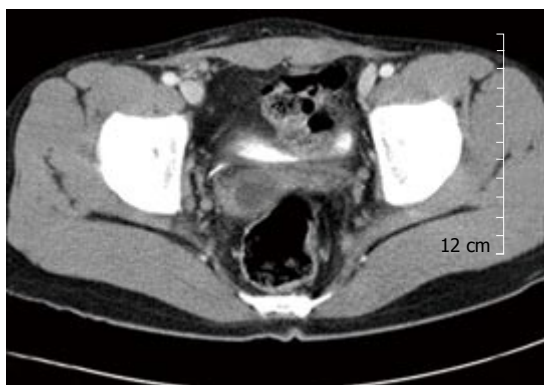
Abdominal computed tomography revealing an oval-shaped cyst with a thickened wall in anterolateral to the rectum.
